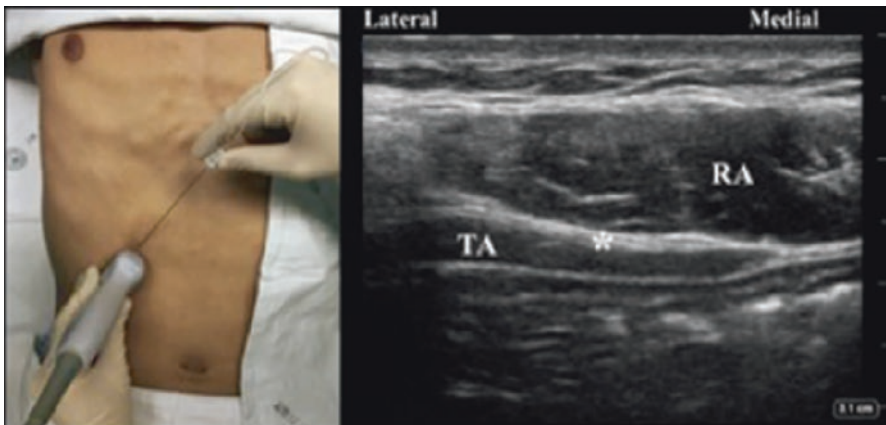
TAP Block US landmark. Ultrasound probe position, needle puncture site, and sonographic image of the subcostal transversus abdominis plane block. Asterisk indicates needle target; RA rectus abdominis muscle; TA transversus abdominis muscle
